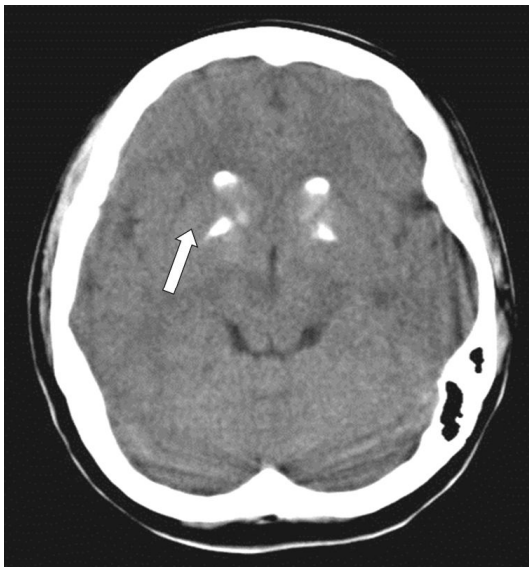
The computed tomography (CT) of brain showed multiple calcification of bilateral basal ganglia.
